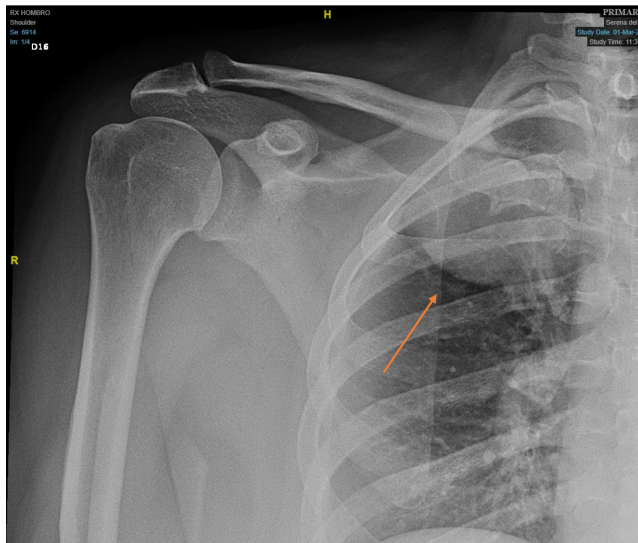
Shoulder X-ray: in the right upper lobe, a well-circumscribed mass is observed (orange arrow).
